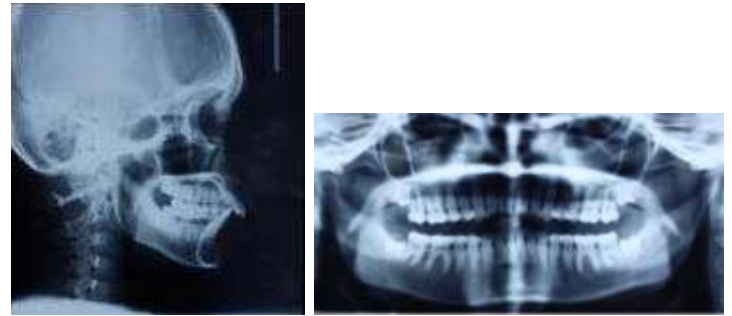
Pre-treatment x-rays
